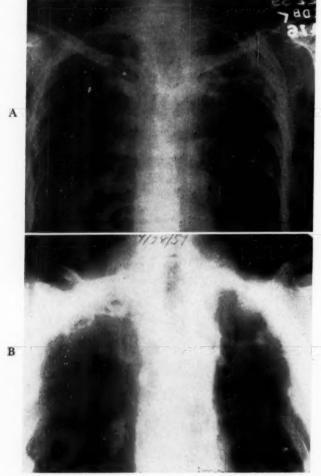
Case 4. A, chest roentgenogram, showing bilateral disease in the upper lobes with cavity on the left. B, laminograph showing details of cavitary disease. These films were taken before fungus ball developed.
